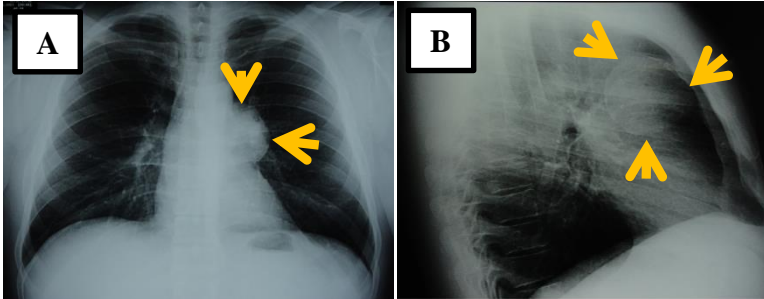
Chest X-ray of ADC of the thymus. Adopted from (Moser, Schiefer et al. 2015).
